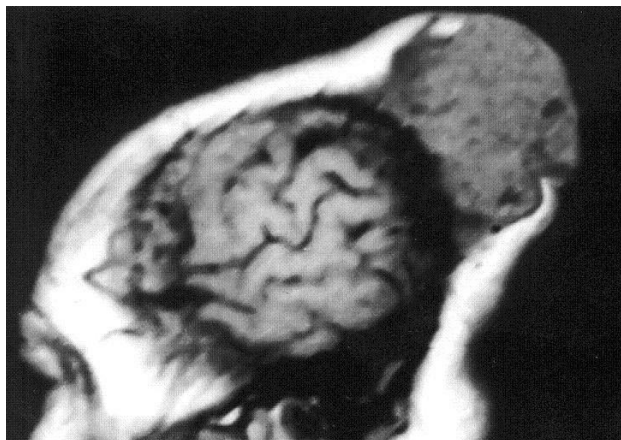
Preoperative post contrast sagittal T1-weighted MRI showing a 7x8x8 cm mass lesion in the left post parietal region expanding and eroding the scalp.
